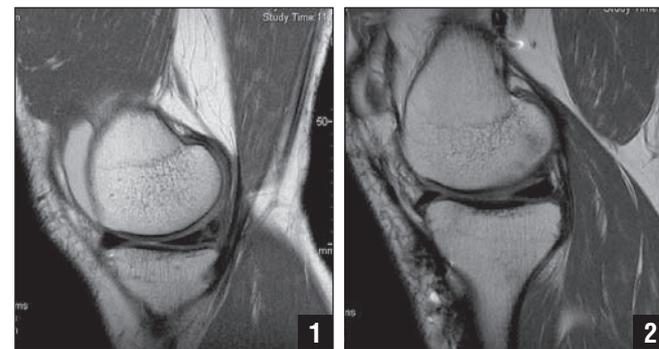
An oblique rupture site clearly seen in the posterior horn of a medial meniscus on sagittal MRI. Figure 2: A healing of the previous meniscal rupture can be seen on 1-year postoperative MRI.
